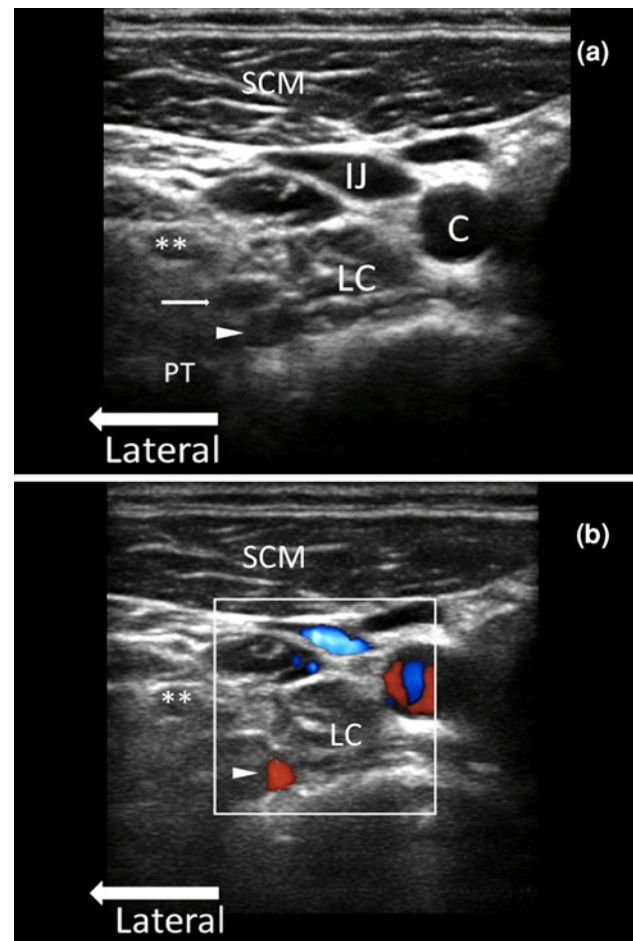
a. Ultrasonographic image of neck at seventh cervical vertebral level (C7). b. Ultrasonographic image of neck at the same level with Doppler imaging. Arrow head = vertebral artery; line arrow = vertebral vein;  = C7 nerve root; C = carotid artery; LC = longus colli muscle; IJ = internal jugular vein; SCM = sternocleidomastoid muscle; PT = posterior tubercle. Reproduced with permission from USRA (<http://www.usra.ca>)
